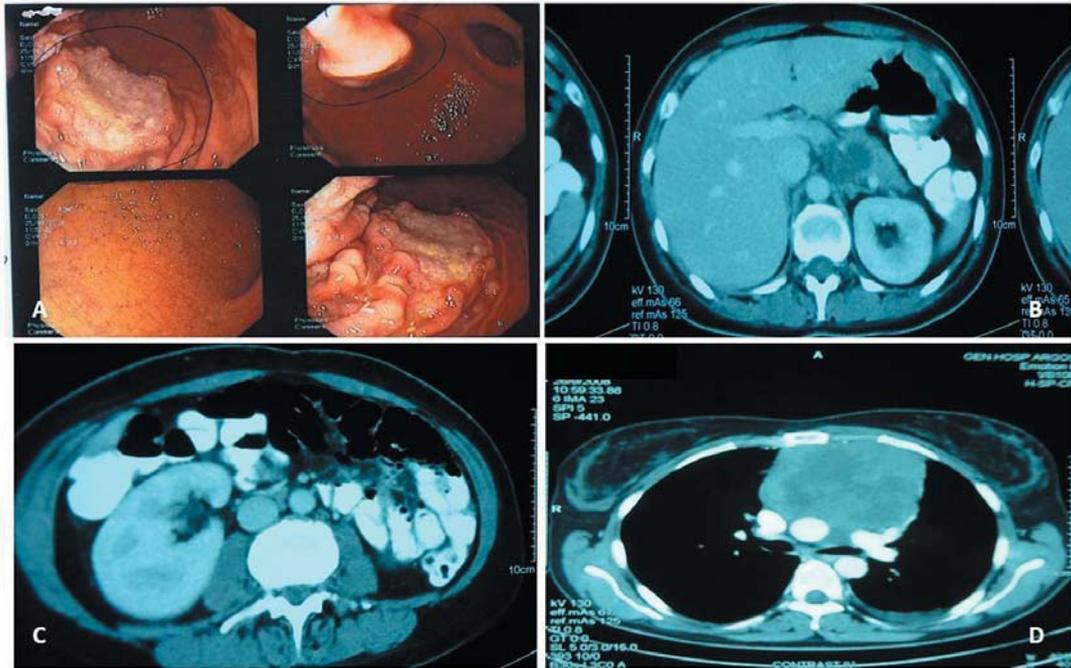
A: Upper gastrointestinal (GI) endoscopy of case 1. Endoscopic appearance of the large ulcerative lesion due to primary mediastinal large B-cell lymphoma (PMBCL) infiltration of gastric cardia and fundus, which also extended to the pyloric antrum. B-D: Computed tomographic (CT) scan of case 1, showing thickening of the gastric wall and retropancreatic lymphadenopathy with central necrosis (B), enlargement of the right kidney with associated hypodense lesions (C), and a large mediastinal mass with multiple foci of necrosis and an associated small left pleural effusion (D).
